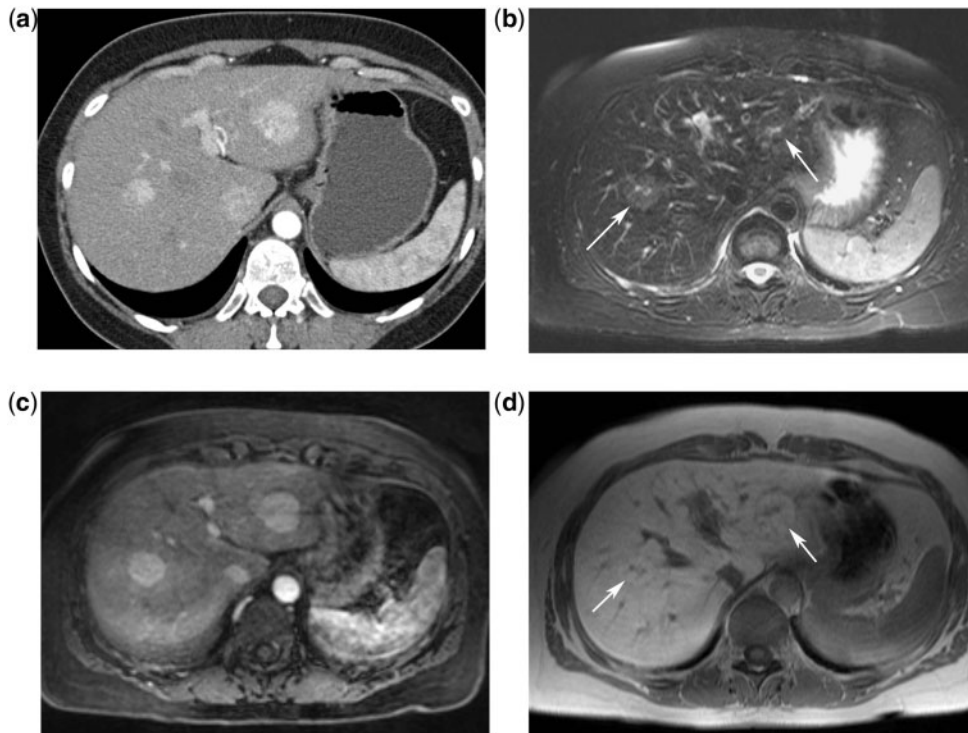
Incidentally detected focal liver lesion. Contrast-enhanced CT in the arterial phase (a) demonstrates 2 hypervascular lesions, which cannot be characterized with certainty. Axial T2-weighted MR image (b) shows the lesion to be isointense with hyperintense central scars (arrows). On the T1-weighted gradient recalled echo (GRE) image in the hepatobiliary phase (d), the lesions are isointense due to hepatocellular uptake of contrast material (arrows). Findings are indicative of FNH.
